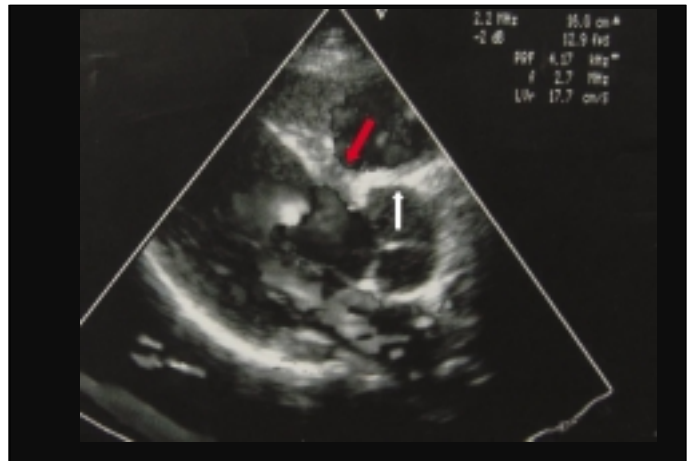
Postoperative echocardiography view is demonstrating no valvular insufficiency and normally functioning tricuspid valve. White and red arrowheads indicate normal tricuspid valve and closed ventricular septal defect, respectively
